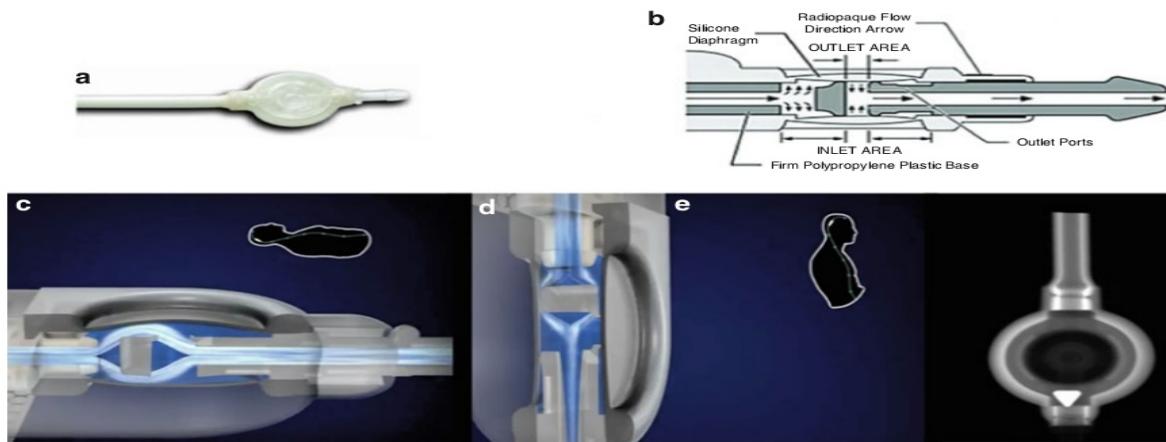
(a, b) Medtronic Delta Chamber (c) The normally closed Delta chamber mechanism (d) opens in response to positive intraventricular pressure. Working with the membrane valve, this mechanism minimizes over-drainage by utilizing the principle of hydrodynamic leverage (e) X-ray appearance.
